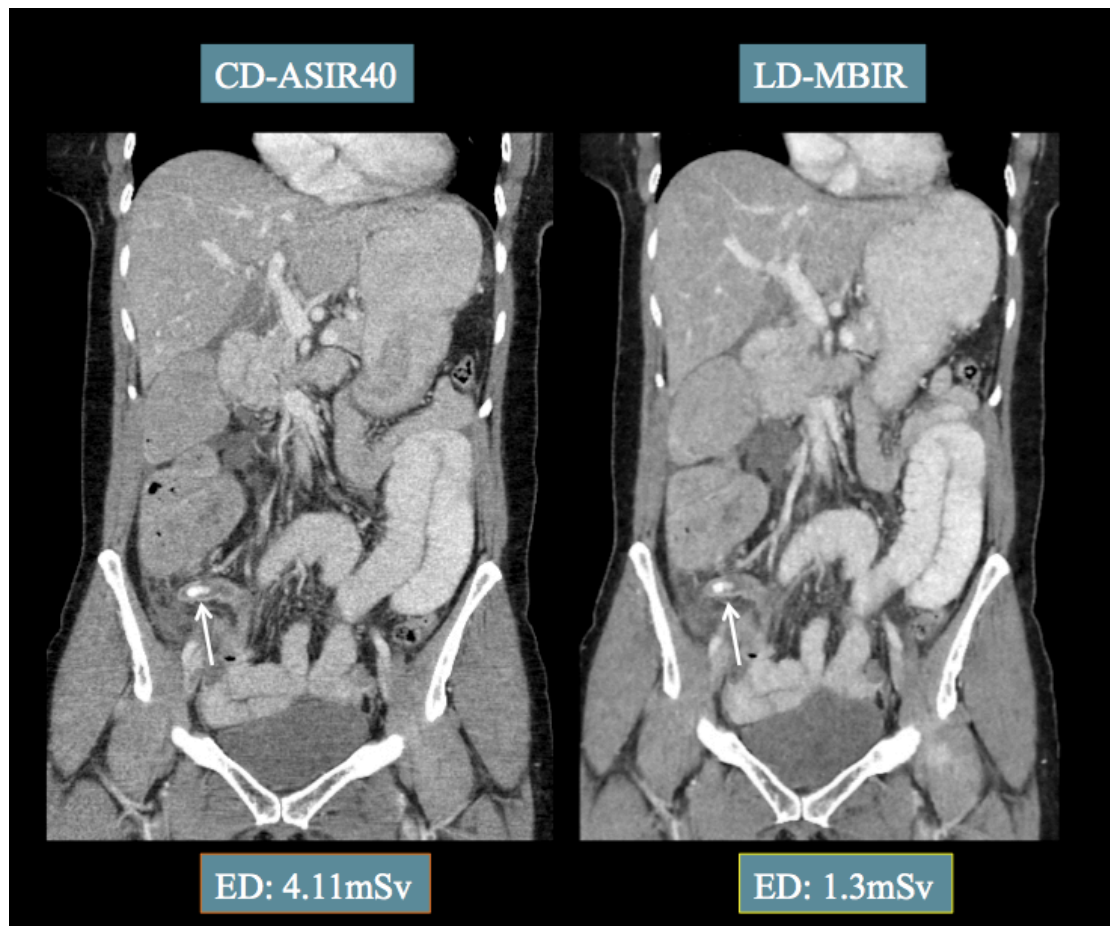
CD ASIR and LD MBIR coronal CT images in a 36 year-old male patient presenting with acute abdominal pain with a suspected diagnosis of acute appendicitis. Both images show an inflamed appendix with a 4 mm appendicolith. The LD MBIR image was acquired at a significantly lower dose than the CD ASIR image.
